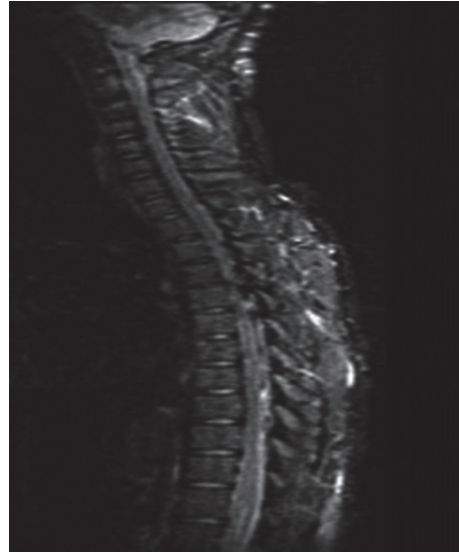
MRI T2 Revealing Hematoma Extending to the Level of C4
